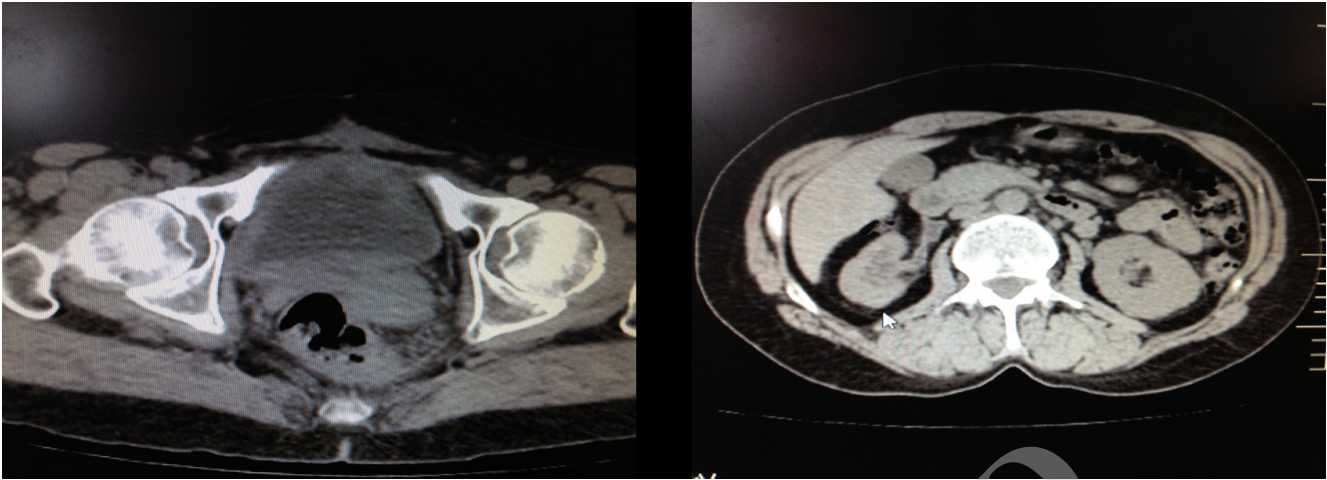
Postoperative computed tomography scan showing no mass and hydronephrosis.
